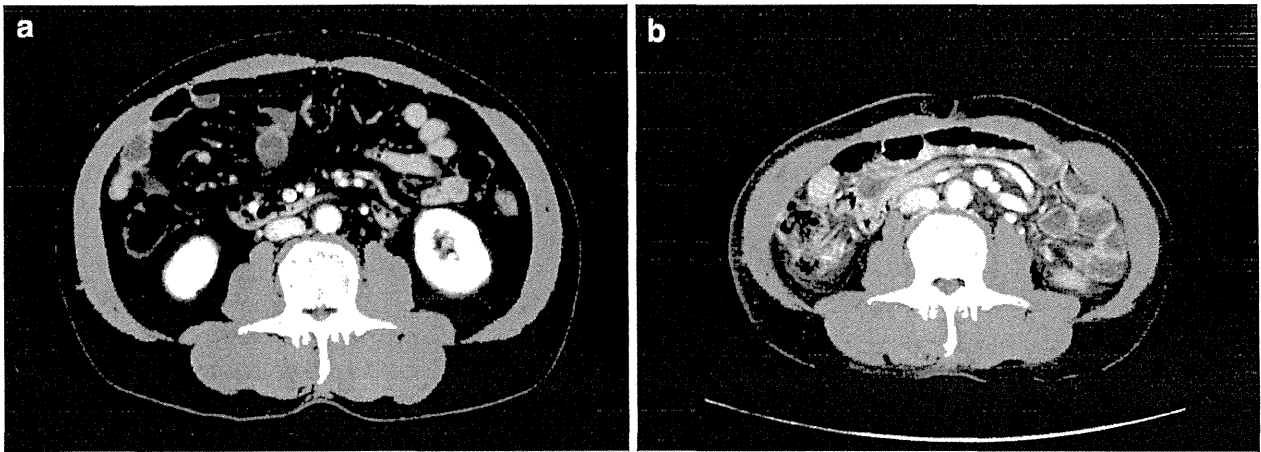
Typical transverse computed tomography (CT) images at L3 show postoperative changes in skeletal muscle (*green*). The preoperative total muscle area of 143 cm² (a) decreased to 122 cm² at 1 year after surgery (b)
